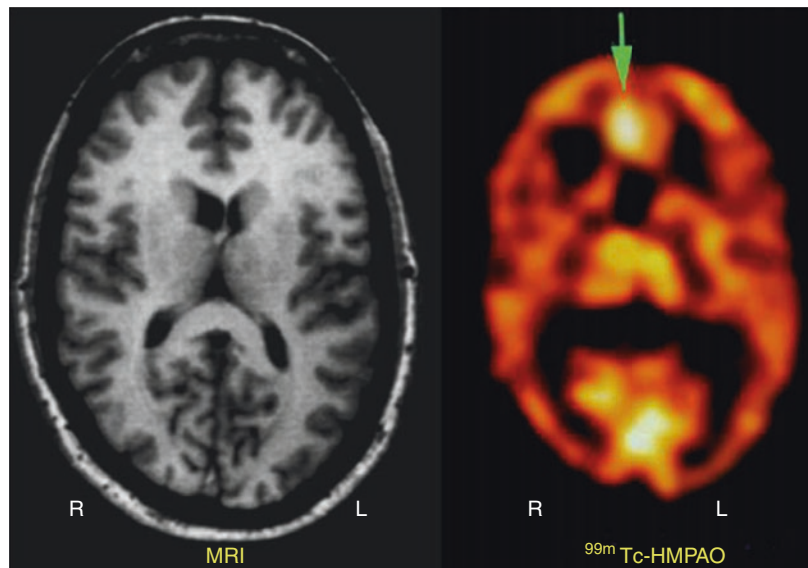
Coronal images from MRI (*left*), ictal ^{99m}Tc -HMPAO SPECT (*middle*), and interictal ^{18}F -FDG PET scan (*right*) of a 42-year-old female with intractable seizures. (*Left*) The MRI scan is normal. *Middle*. The ictal ^{99m}Tc -HMPAO brain SPECT scan showed a focal area of significant hyperemia in the right mesial frontal lobe (*arrow*). (*Right*) There was minimal reduction of ^{18}F -FDG
